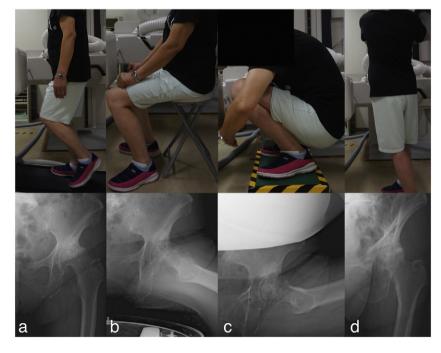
Patients with osteoarthritis of the hip joint walked on a level treadmill at 1.0 km/h (a), got up from a chair (b), stood from a position with maximum hip flexion (c), and rotated the trunk bilaterally from a neutral standing position (d) under radiographic surveillance.
